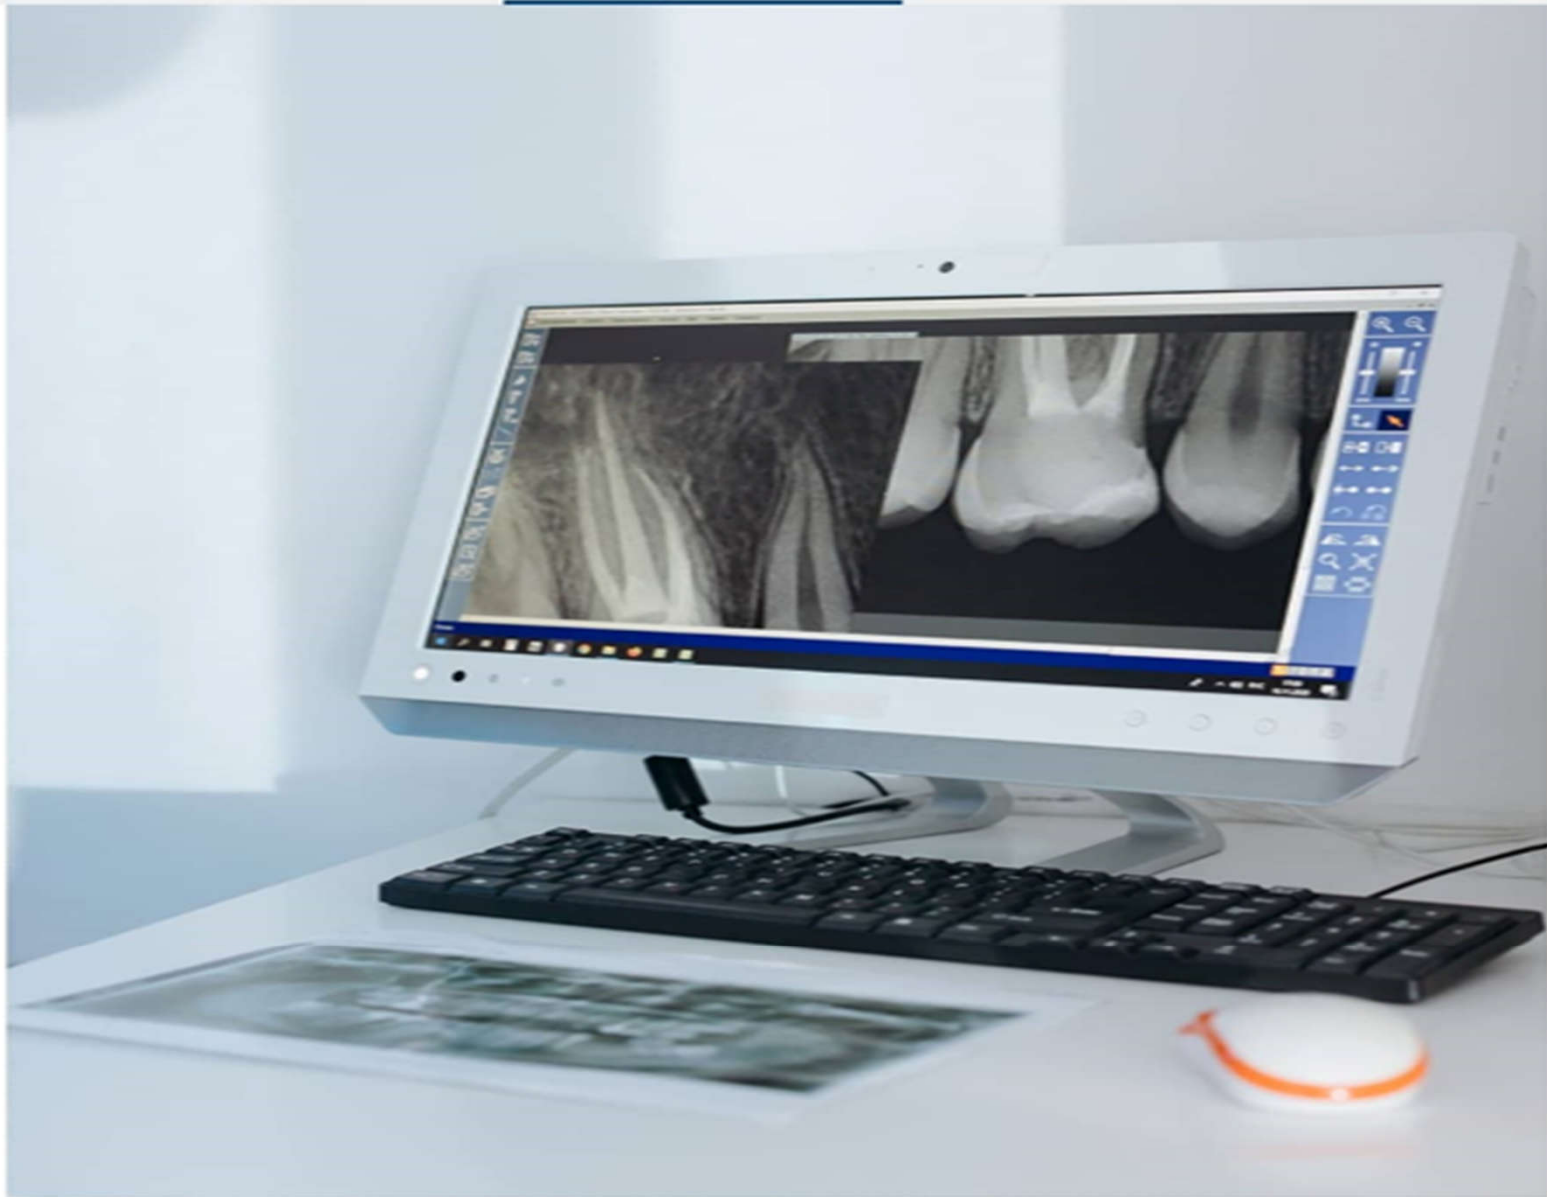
An AI model can automatically diagnose osteoporosis from hip X-rays (Photo courtesy of Pexels)
